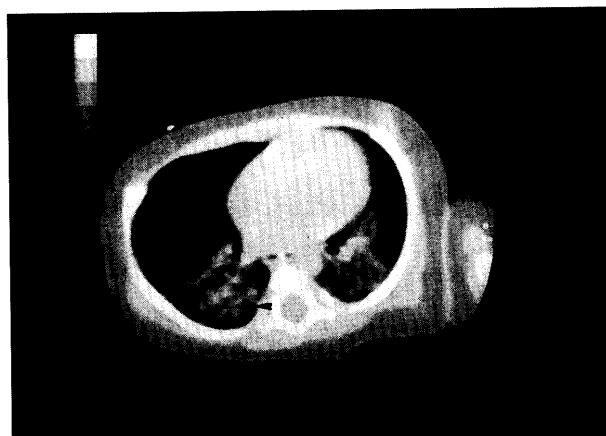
Thoracic CT scan. The presence of a bilateral ground-glass pattern is found (*arrow*).
